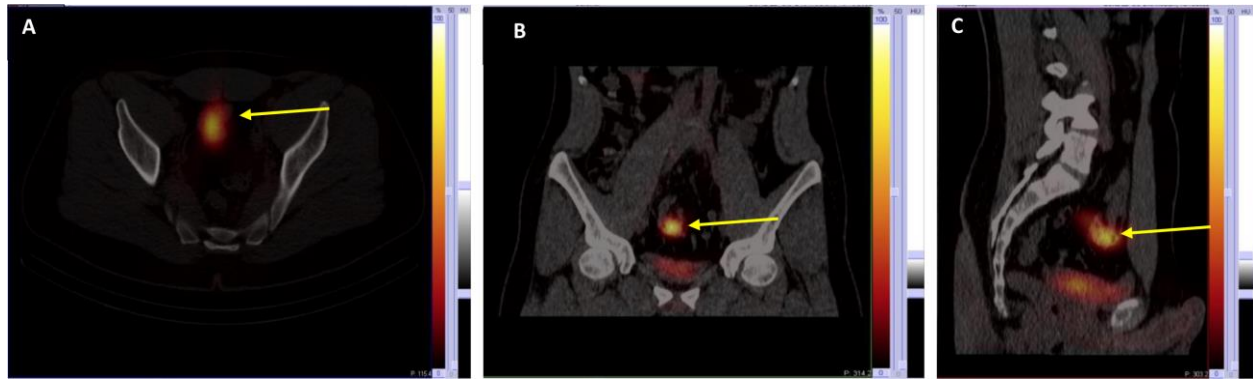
Tc99m pertechnetate nuclear medicine scan, SPECT/CT A axial, B coronal and C sagittal. SPECT/CT views were required for conformation and anatomical purpose. The focal abnormal activity was increase during the scanning time suggesting active bleeding by Meckel's Diverticulum (*yellow arrows*).
